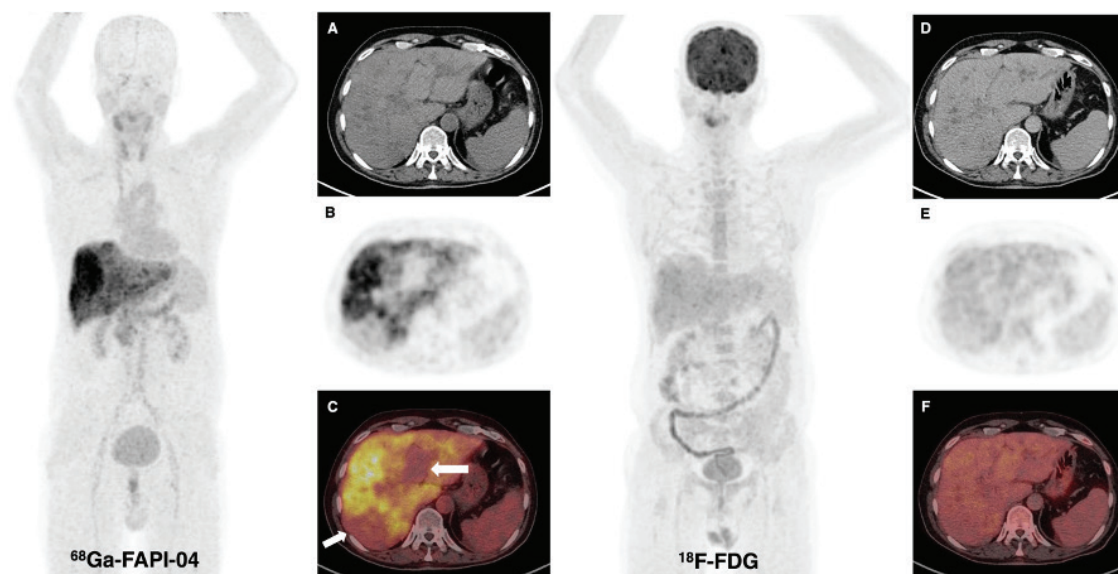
^{18}F -FDG and ^{68}Ga -FAP-04 PET/CT imaging were performed on a 55-year-old patient who was investigated for a liver malignancy that may occur on the basis of cirrhosis. Heterogeneous intense FAPI uptake was detected in the liver, especially in the right lobe, whereas there was no significant pathological uptake apart from parenchymal areas protected from cirrhosis [(A) CT, (B) PET, (C) fusion images] and no prominent liver activity on ^{18}F -FDG PET/CT [(D) CT, (E) PET, (F) fusion images]. In addition, mild to moderately increased thyroidal uptake suggestive of thyroiditis was revealed on the maximum intensity projection image of ^{68}Ga -FAP-04 PET/CT.
